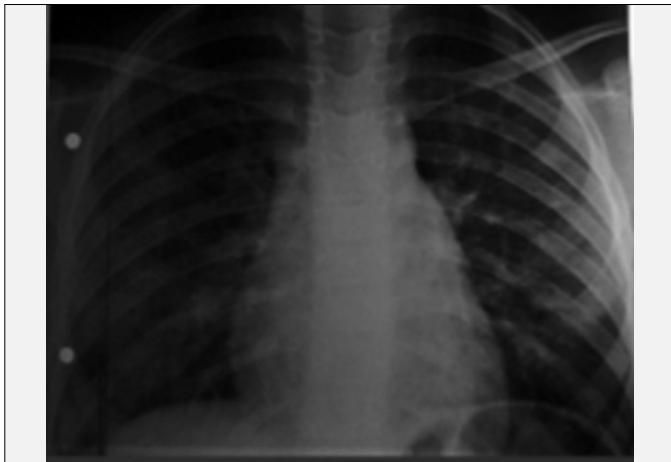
Bilateral nodular lesions on chest x-ray
